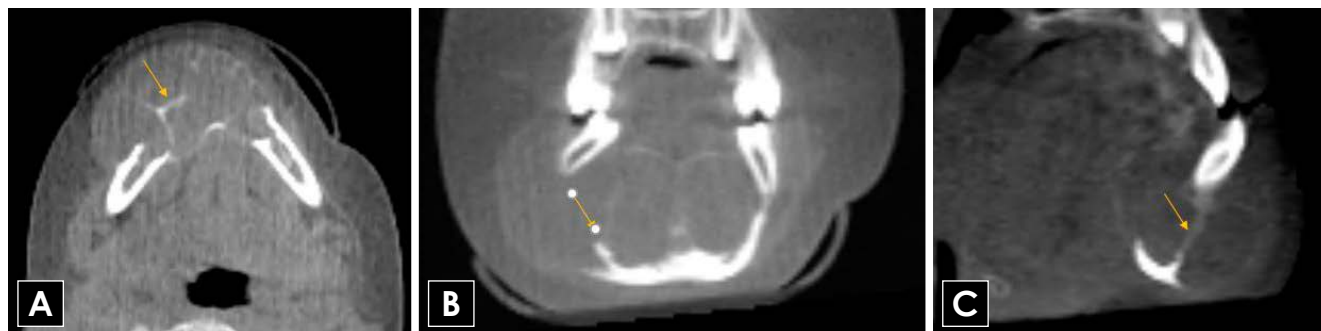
Axial (A), coronal (B), and sagittal (C) CBCT images indicate an example of an expansile multilocular low-density lesion involving the anterior region of the mandible. Considerable bone expansion is evident buccally. Note the wispy/granular septations within the lesion (arrows). CBCT: cone-beam computed tomography.
